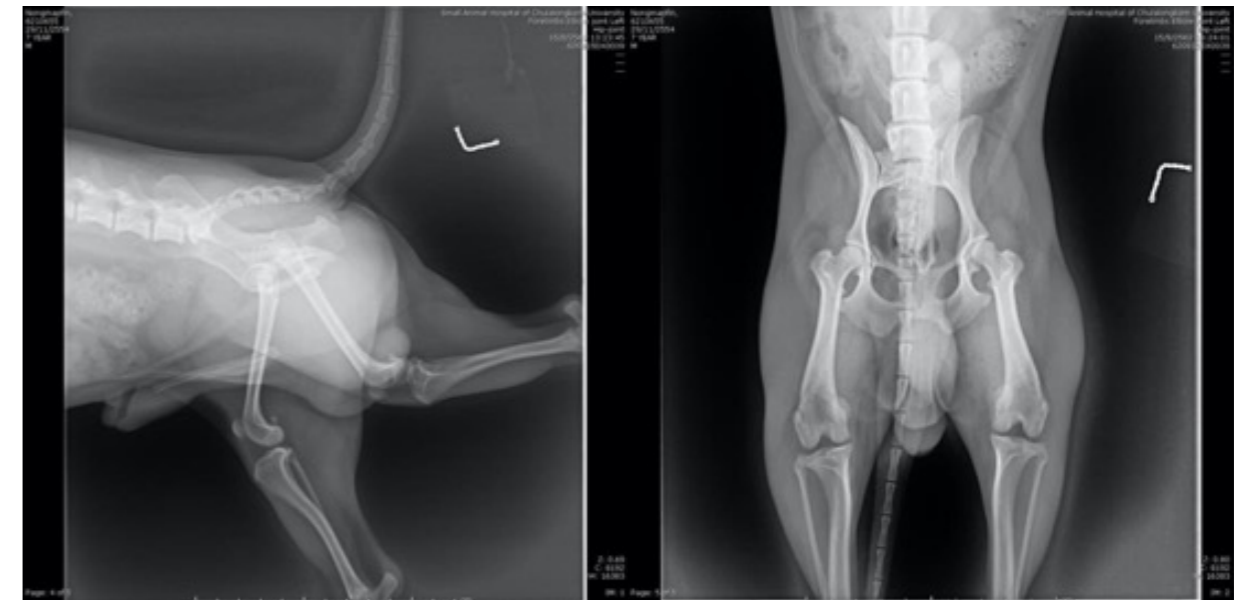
Radiographic images from ventrodorsal view showing patella luxation towards medial trochlear groove (medial patella luxation) on both sides
